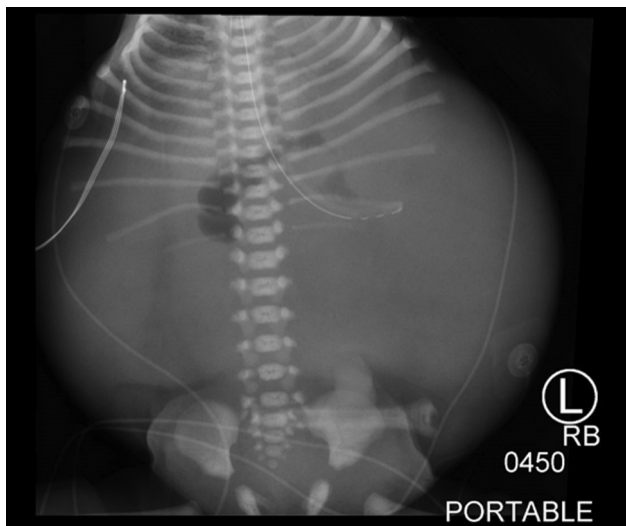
Neonatal X-ray on day of life 0.
